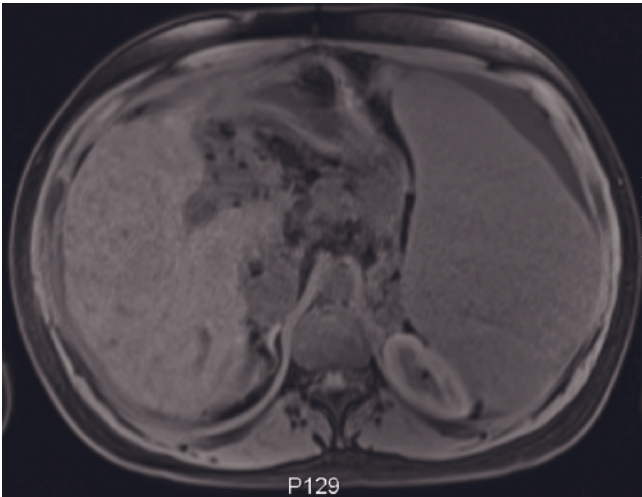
(Continued) spin-echo (f), axial T1-weighted MPRAGE (g), axial T1-weighted immediate postgadolinium WE-MPRAGE (h), axial T1-weighted 60-s postgadolinium fat-suppressed WE-MPRAGE (i), and axial T1-weighted 90-s postgadolinium WE-MPRAGE (j) images of a 2-year-old female with nephroblastomatosis.
